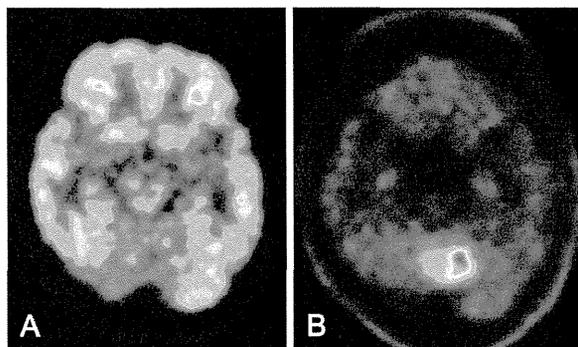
Results for ^{18}F -fluoro-deoxy-glucose (FDG) (a) and ^{11}C -methionine (b) positron emission tomography (PET). Compared with normal cerebellar cortex, lower (L/N, 0.62) and higher (L/N, 2.73) accumulations are observed, respectively
